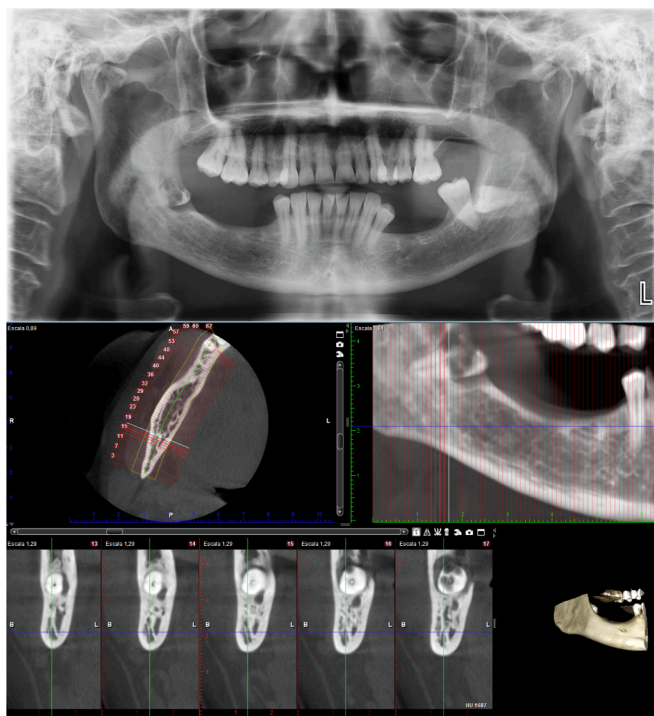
Root apex lower 3 M-IAN relationship in the OPG and CBCT.
